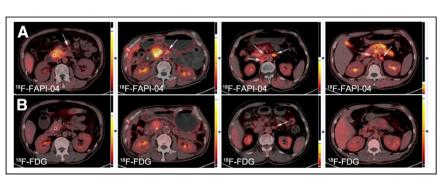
Typical LN PET/CT images obtained with ¹⁸F-FAPI-04 (A) and ¹⁸F-FDG (B) from 4 patients. Lesion is marked by arrows.
